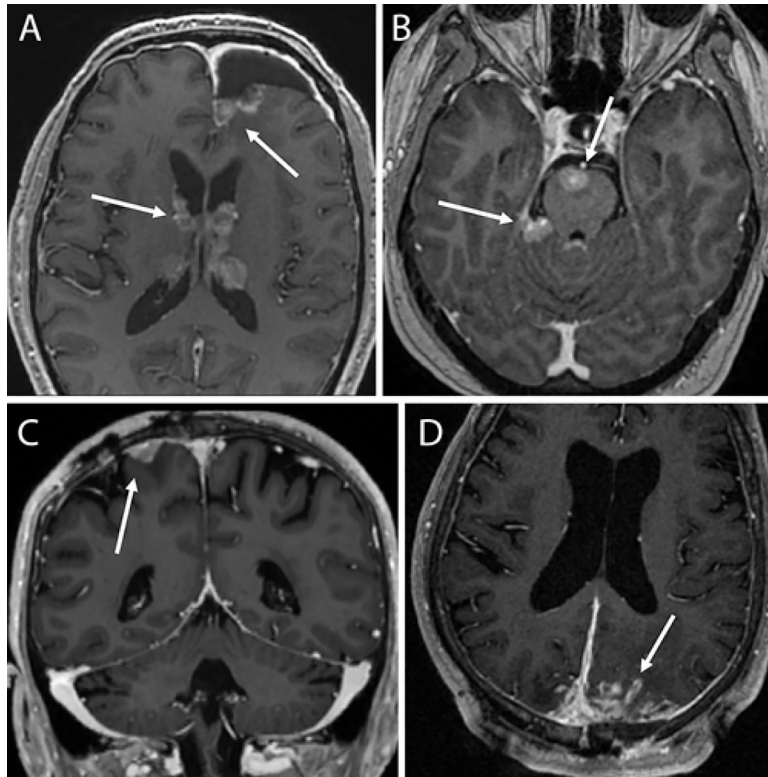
Axial (A, B, and D) and coronal (C) MR images showing examples of postoperative nLMD (*arrows*). Sites of nLMD were outside prior radiation fields.
